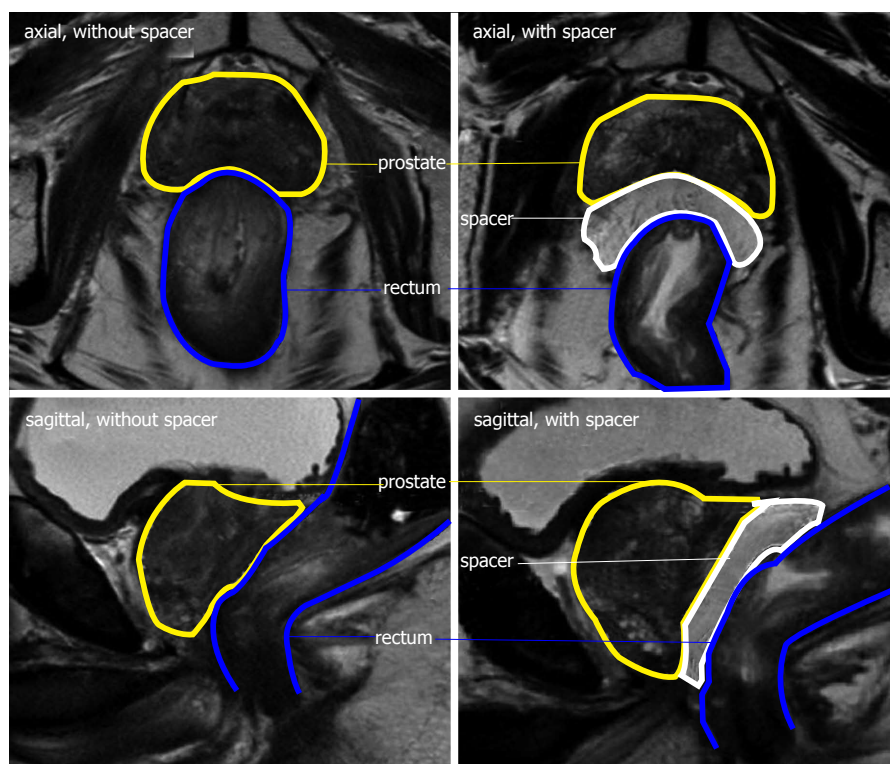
T2 weighted magnetic resonance imaging without (left) and with (right) a hydrogel spacer. Spacer hyperintense, resulting in > 1 cm separation between prostate and rectum.
